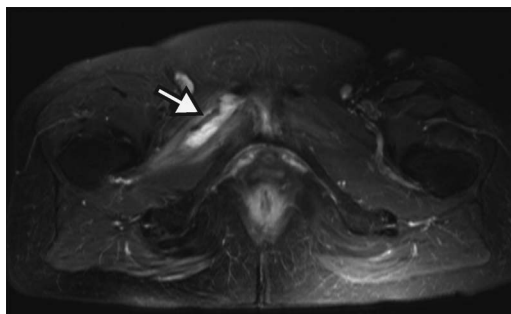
Axial T2-weighted magnetic resonance image showing the right obturator externus muscle pyomyositis and oedema of adjacent tissues.
